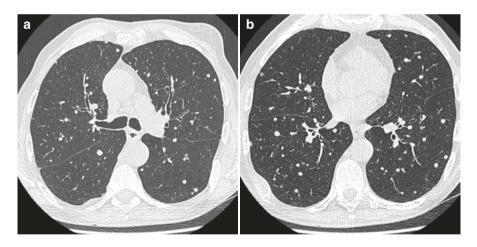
(a) HRCT of the lungs: multiple nodules. (b) HRCT of the lungs: multiple nodules in both lungs. (c) HRCT of the lungs: multiple nodules mainly in dorsal parts of both lungs. (d) HRCT of the lungs (coronal reconstruction): multiple nodules, mainly in random distribution. (e) HRCT of the lungs (sagittal reconstruction): multiple nodules in a random distribution. (f) HRCT of the lungs (MIP reconstruction): multiple nodules. (g) HRCT of the lungs (MIP, coronal reconstruction): multiple nodules. (g) HRCT of the lungs (MIP, coronal reconstruction): multiple nodules in a random distribution. (h) HRCT of the lungs (MIP, sagittal reconstruction): multiple nodules in a random distribution. (i, j) HRCT of the lungs (MIP, sagittal reconstruction): multiple nodules in a random distribution. (i, j) HRCT of the lungs (bone window): osteolytic lesion of the rib on the right side. (k) HRCT of the lungs (mediastinal window): in the left breast, homogeneous soft-tissue nodule deposit with non-sharp edges—left breast tumour. (l) HRCT of the lungs (mediastinal window, coronal reconstruction): in the left breast, homogeneous soft-tissue deposit with non-sharp edges—left breast tumour. (m) HRCT of lungs (mediastinal window, sagittal reconstruction): in the left breast tumour. (m) HRCT of lungs (mediastinal window, sagittal reconstruction): in the left breast tumour. (m) HRCT of lungs (mediastinal window, sagittal reconstruction): in the left breast tumour.
